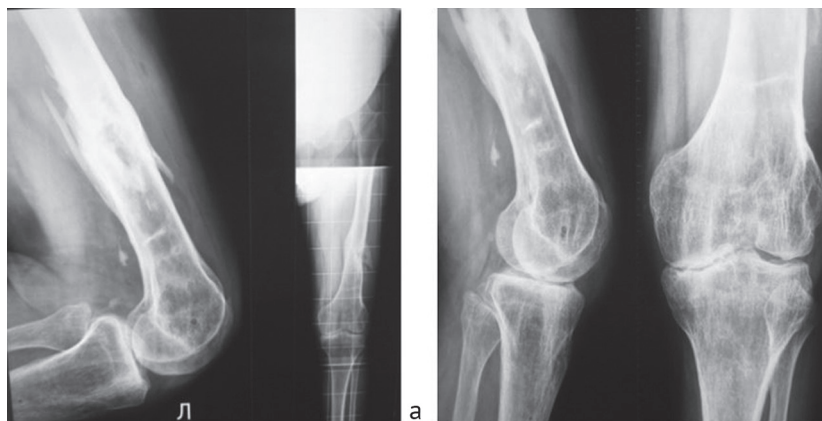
Patient S.: a radiograph of the left femur after removing the plate. Consolidated fracture of the lower third of the femur; b radiograph of the knee joint before joint replacement
